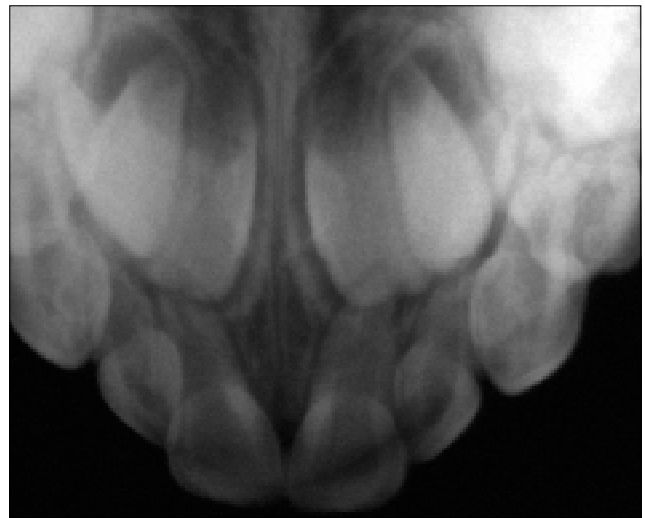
Radiograph of maxillary teeth taken two weeks after trauma
